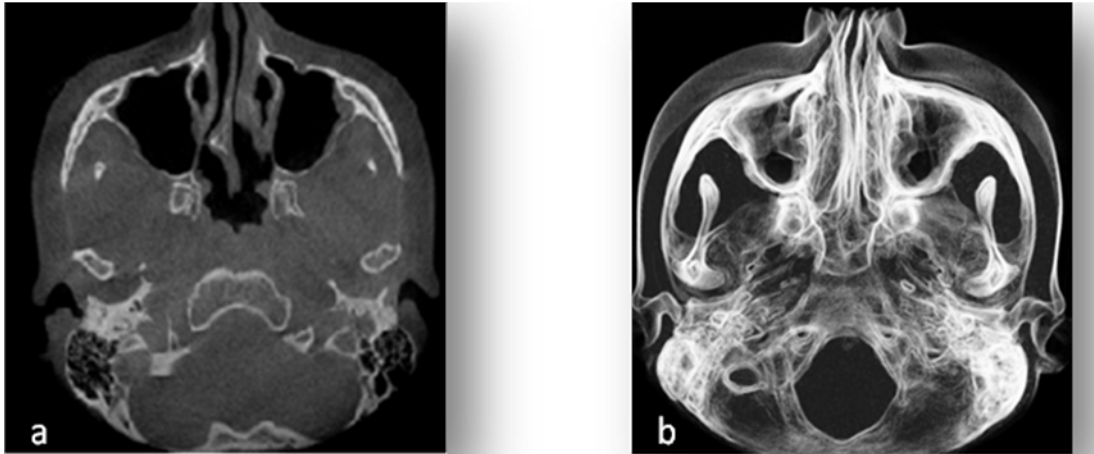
a) Raw data of a single CBCT slice (0.3mm). b) Image "a" processed, integrating 20 slices; this image offers more contrast and can be analyzed from a 3D point of view.
